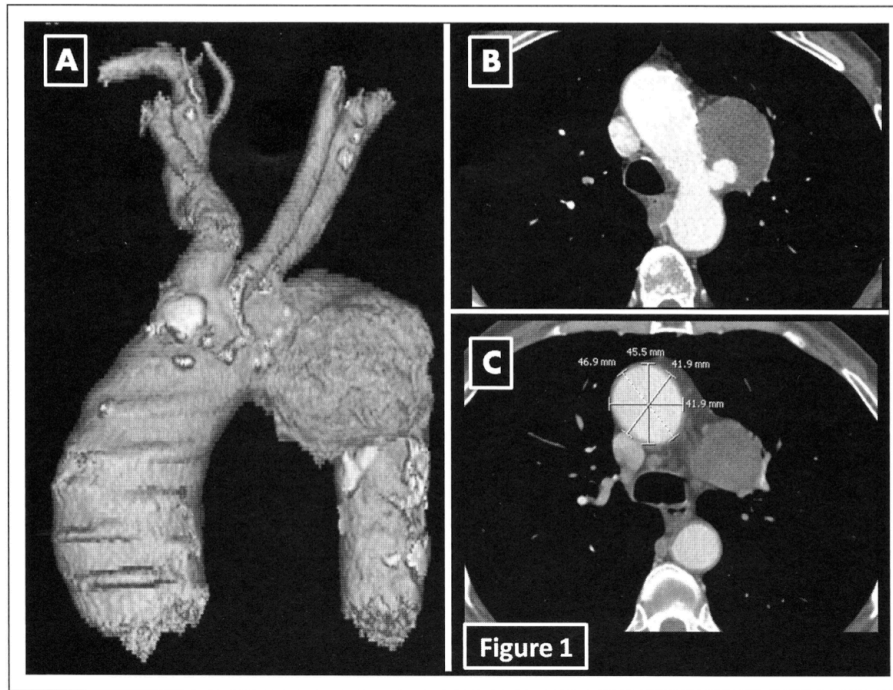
Preoperative computed tomography angiography. A, Three-dimensional reconstruction showing ductus Botalli and ascending aortic aneurysms. B, Residual ductus Botalli aneurysm in axial view. C, Ascending aortic aneurysm (maximal diameter of 47mm).
